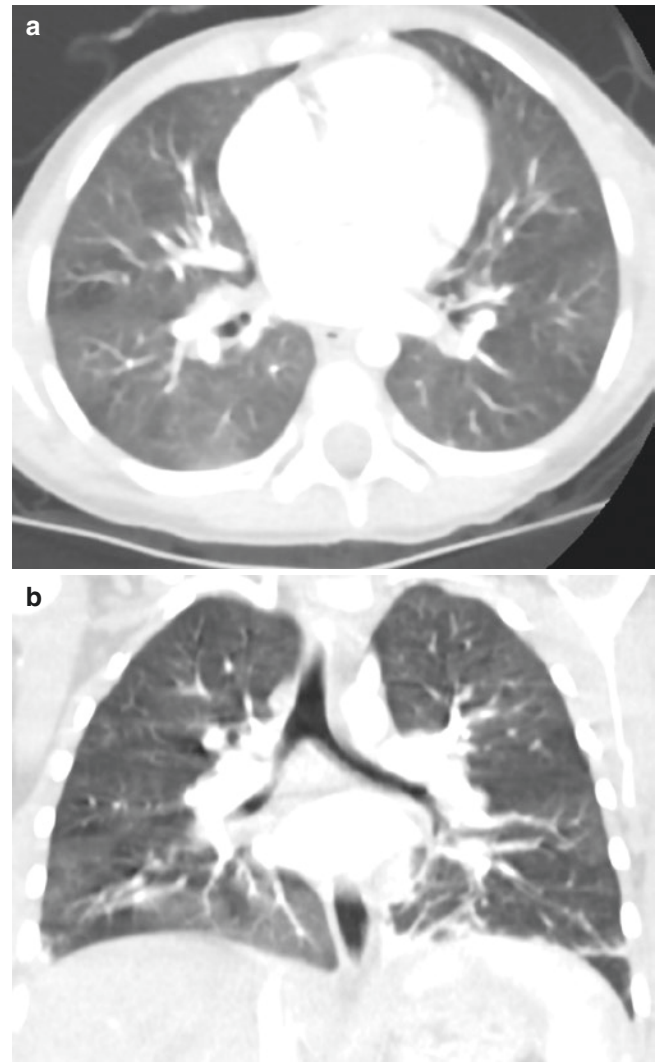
(a) A young girl presented with anemia, recurrent infections, plus frequent cough and wheezing, was found to have short telomere syndrome due to a *TERT* mutation. Axial views of the chest CT reveal bilateral, patchy ground-glass opacities and atelectasis. (b) Coronal reconstructions of the chest CT imaging of this young girl with short telomere syndrome again show diffuse patchy ground-glass opacities and subsegmental atelectasis, underscoring the diffuse lung disease associated with the pulmonary fibrosis seen in this disease
